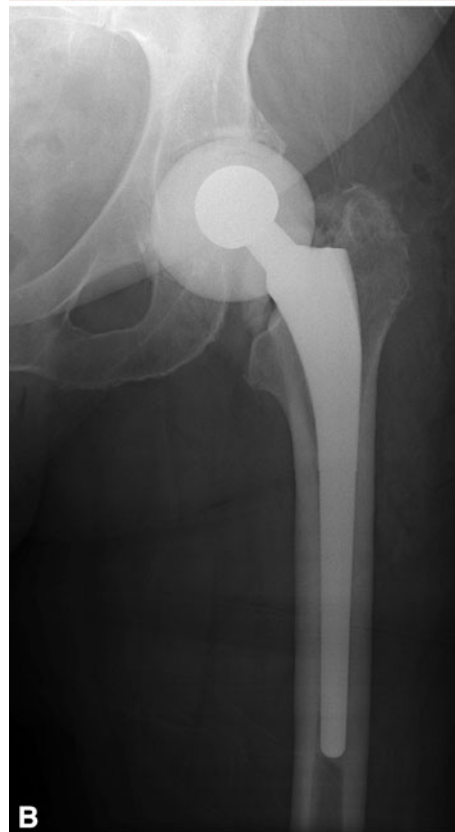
B (A) To fabricate a larger articulating spacer (outer diameter, 52 mm), a bulb-type irrigation syringe (CR Bard, Inc) may be used to mold the antibiotic-laden cement. (B) Radiograph reveals an interim articulating cement spacer molded with a bulb-type irrigation syringe.
